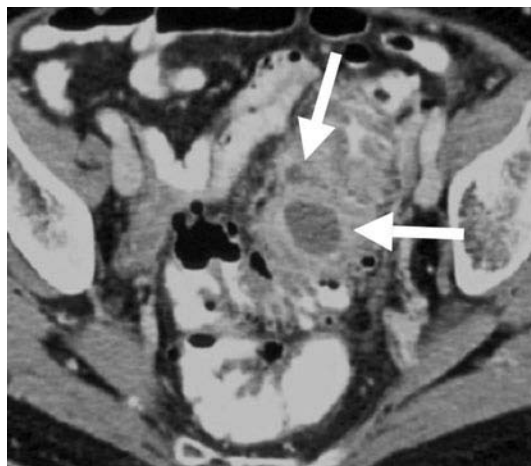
Sigmoid diverticulitis with pericolic abscesses. CT shows fine linear strands within pericolic fat, diverticula filled with air, barium, or fecal material, circumferential bowel thickening, and frank abscesses (arrows)
